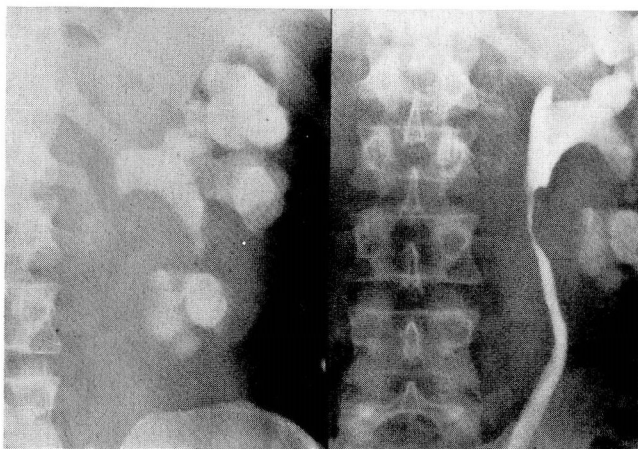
A plain radiograph (left) shows a recurrent staghorn calculus in a 43-year-old man with a solitary left kidney. An intravenous pyelogram (right) demonstrates a stricture of the upper ureter caused by fibrosis following a prior operation. Extracorporeal pyelolithotomy and autotransplantation were performed.
